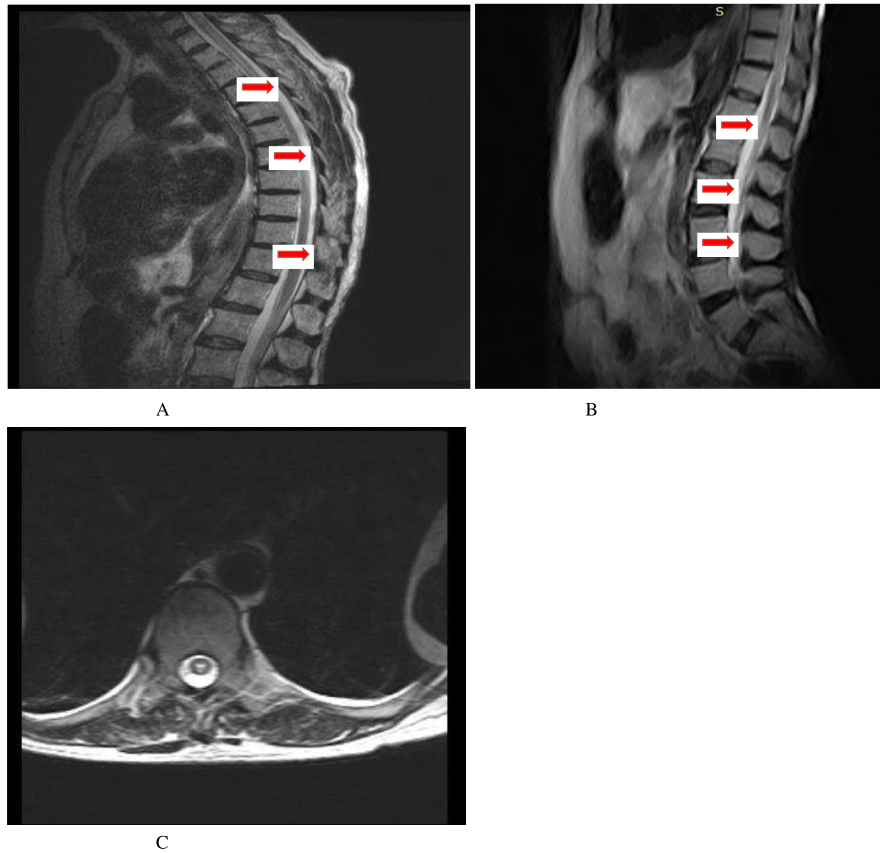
Spinal cord MRI (A–C). There is increased T2 signal of the thoracic cord starting from C7 level and involving the whole thoracic cord up to the level of distal cord (Longitudinally extensive transverse myelitis, LETM red arrows) with possible development of syrinx.
